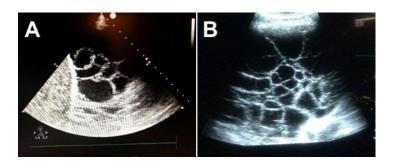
Ultrasound of the right chest, mid axillary line, coronal view.
